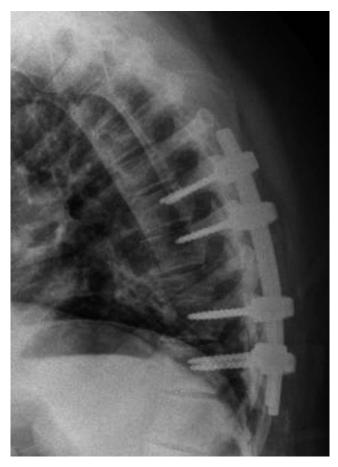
Postoperative sagittal x-ray of the spine showing instrumentation.
